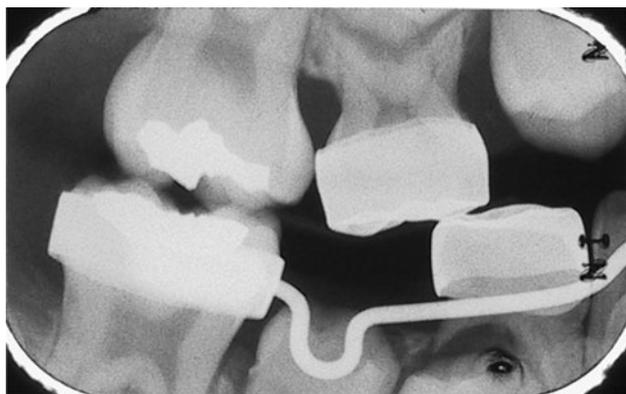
Follow-up radiograph after 6 years showing eruption of the second premolar into a good position with a lower holding arch in place
